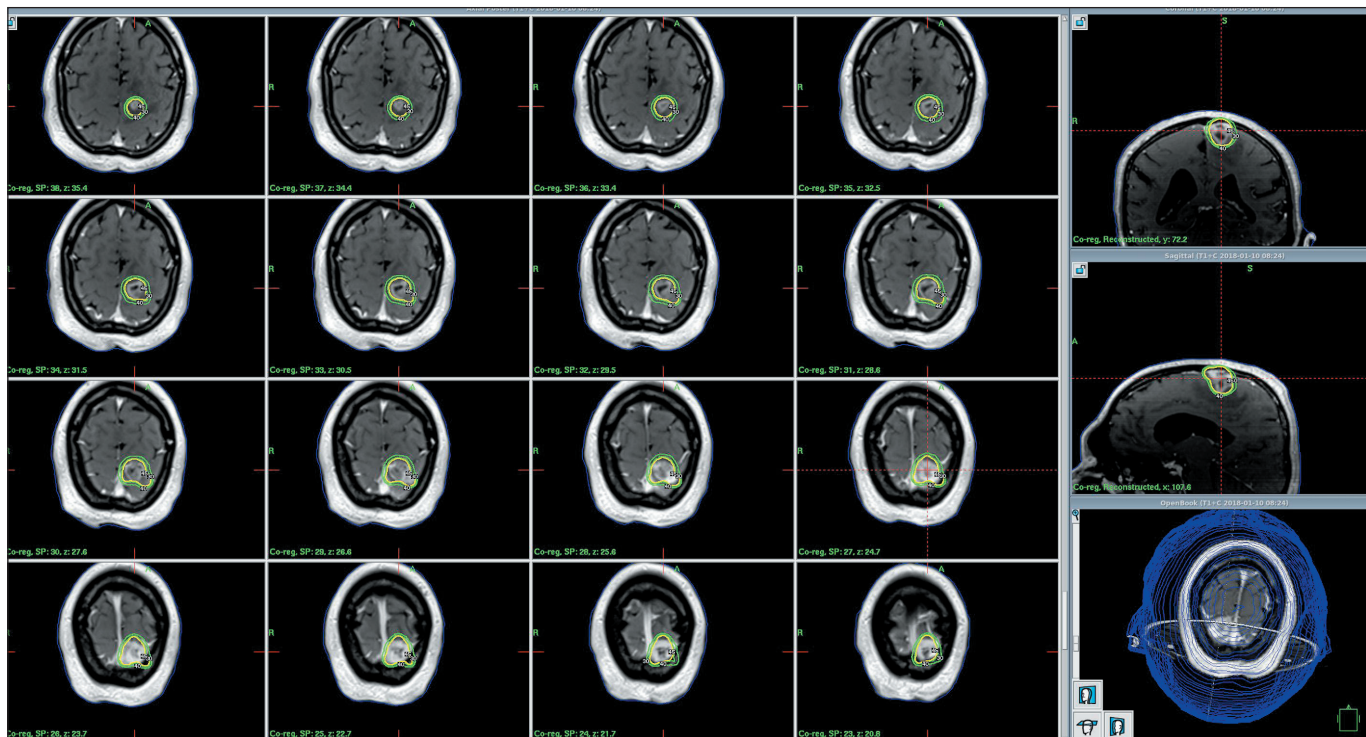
Gamma Knife treatment plan for a brain metastasis from thyroid carcinoma. Axial, coronal, and sagittal post-contrast T1-weighted MRIs show a single parenchymal brain metastasis originating from thyroid carcinoma. The lesion is delineated by the yellow contour line, representing the gross tumor volume. The green isodose lines indicate the radiosurgical dose distribution, which conforms tightly to the tumor borders. High conformality and a steep dose fall-off are achieved to minimize radiation exposure to the surrounding normal brain tissue.
